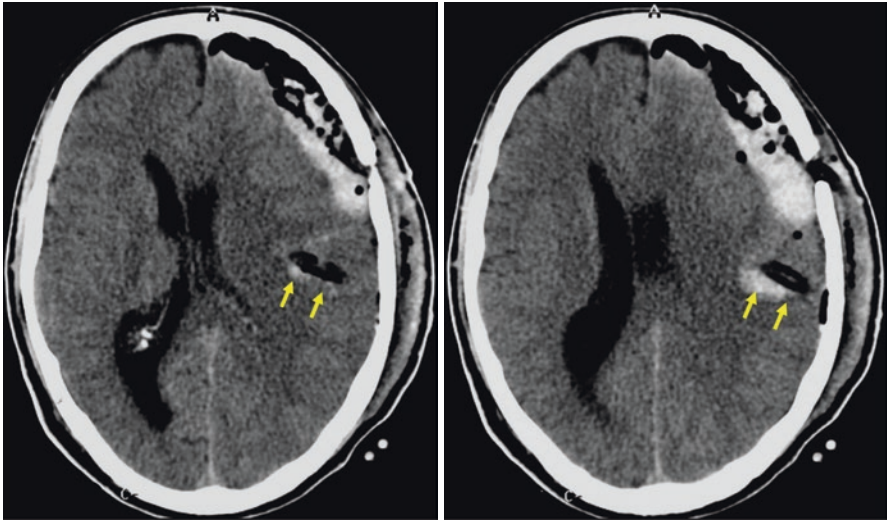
Postoperative axial CT scan showing intraparenchymal deep brain contusions (arrows) following wrong drainage insertion of a chronic SDH
